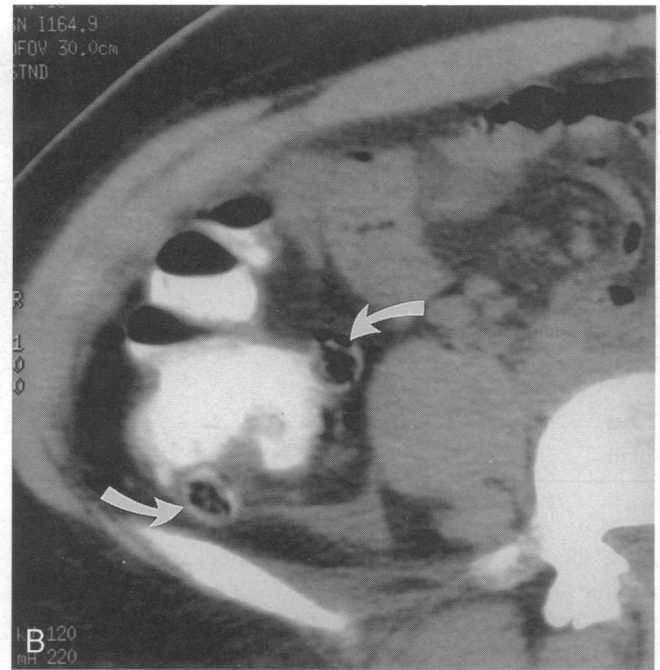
Axial CT scans of a 27-year-old woman with multiple right-sided diverticula (arrows) and adjacent inflammatory fat stranding and fluid, findings consistent with right-sided diverticulitis.
